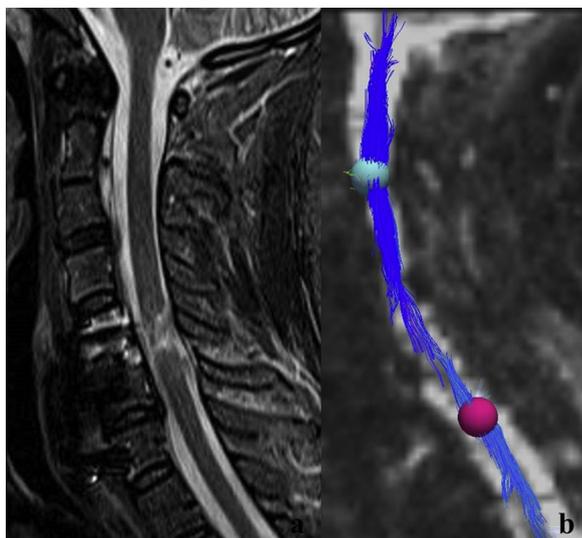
(a and b) 31- year-old male after car accident. C5-C6 luxation with paraplegia and T5 anesthesia. Fixation at 24 h. Bilateral forearm flexion but no finger movements bilaterally. STIR -T2-weighted midsagittal MR image (a): Bondurant grade 4 spinal cord. DTI through a two ROIs approach showing some spared fibers across the lesion (b). Courtesy of Professor Roberto Gaspararotti, Neuroradiology, Spedali di Brescia (IT).
